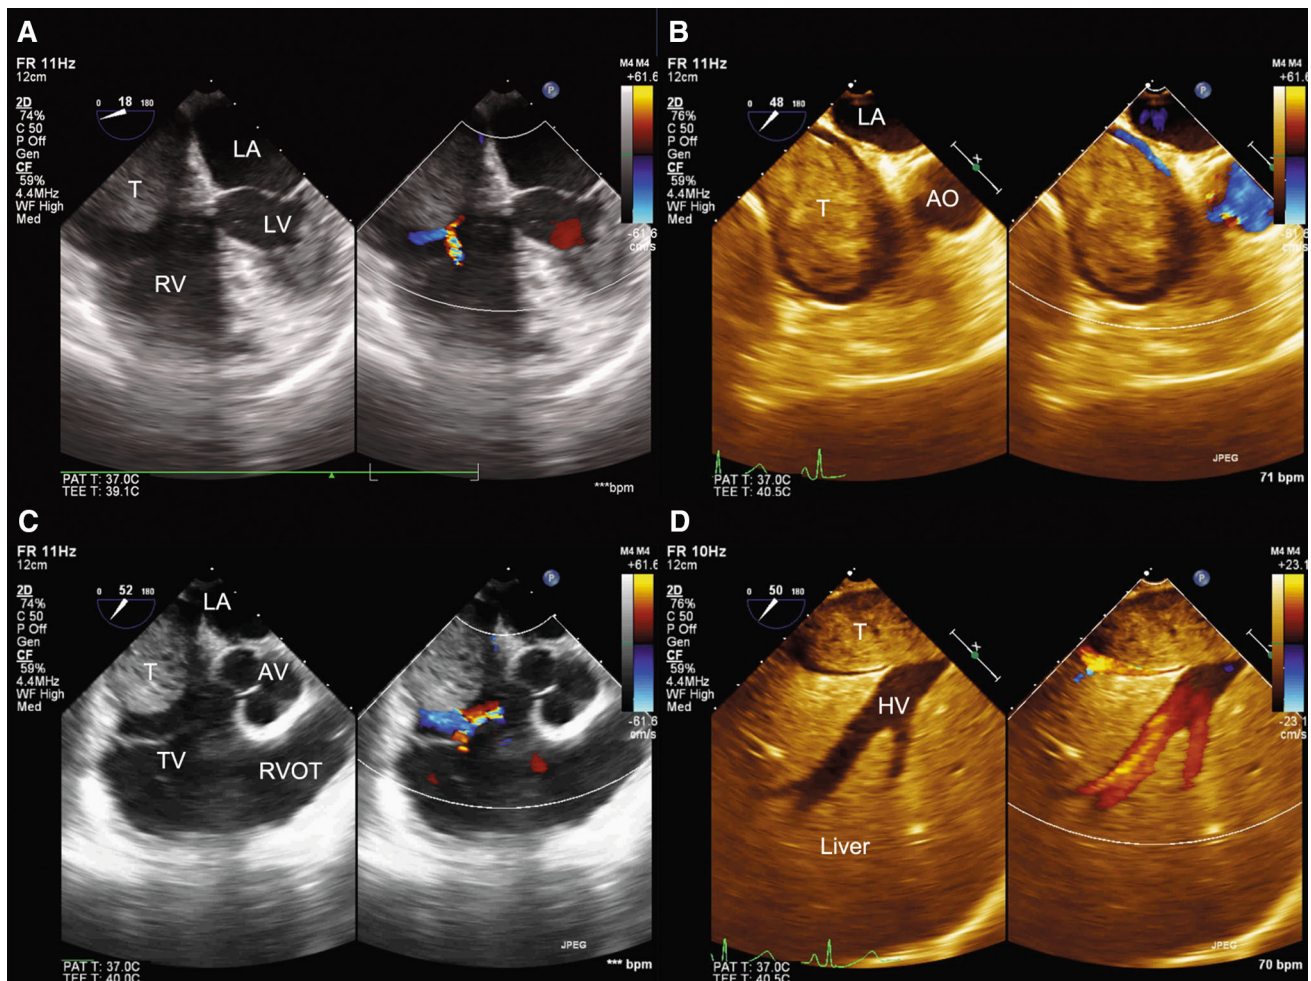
Intraoperative transesophageal ultrasound examination before surgical manipulation of the tumour. A) A modified mid-esophageal four-chamber view showing an oval cardiac end of the tumour floating in the right atrium and a slight tricuspid regurgitation detected by color flow Doppler imaging during systole. B) A modified mid-esophageal right ventricular inflow view showing the cardiac end of the tumour with no intracardiac attachment. C) A mid-esophageal right ventricular inflow-outflow view showing no tumour in the right
